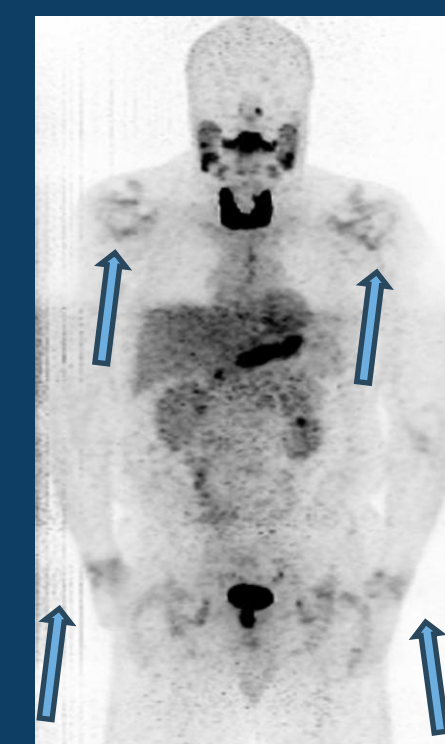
Representative Examples of ¹²⁴I-evuzamitide uptake in a patients with biopsy-proven wild type ATTR-CM while bone scintigraphy and CMR were not suggestive.
